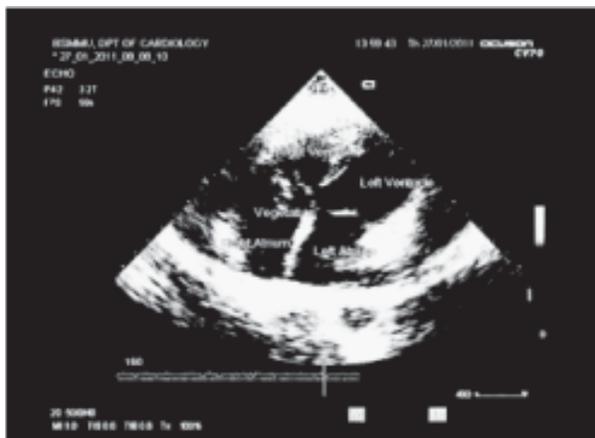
1 & 2: Transthoracic echocardiography reveals- mobile mass attached to pace maker lead near Tricuspid valve.
